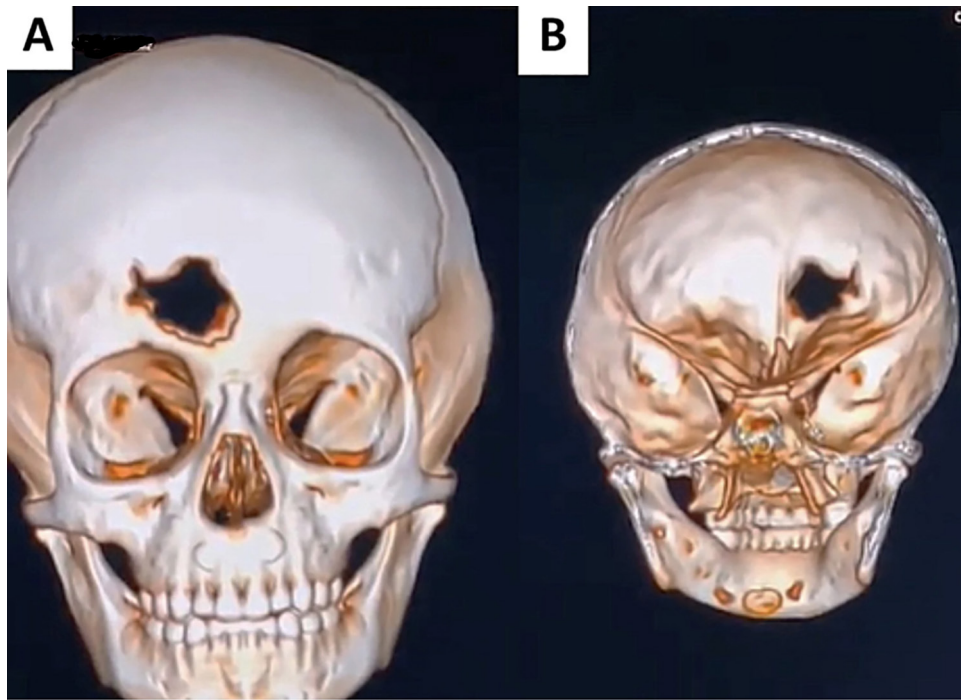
The three-dimensional reconstructed computed tomographic images demonstrate a well-defined osteolytic lesion measuring approximately 4 cm in diameter in the frontal bone. Panel A shows the external view, and Panel B shows the internal view.
